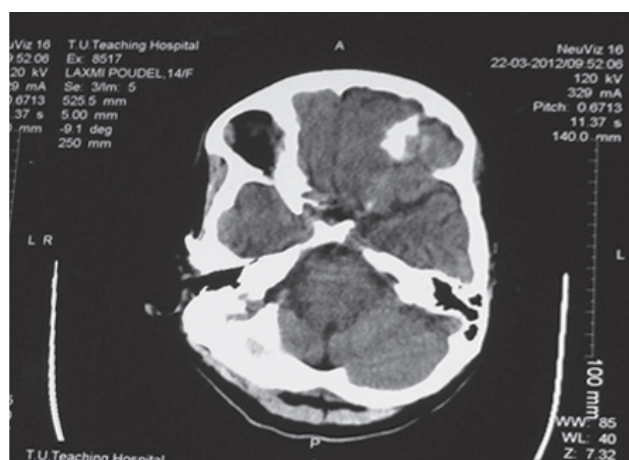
CT scan head with resolving subdural haemorrhage (SDH)
